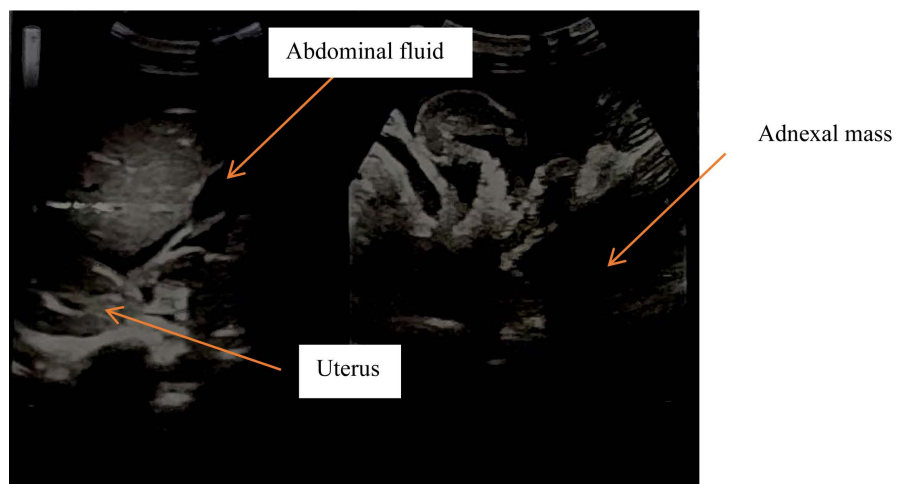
Ultrasound appearance of an empty uterus, abdominal fluid, and an adnexal mass without cardiac activity.
